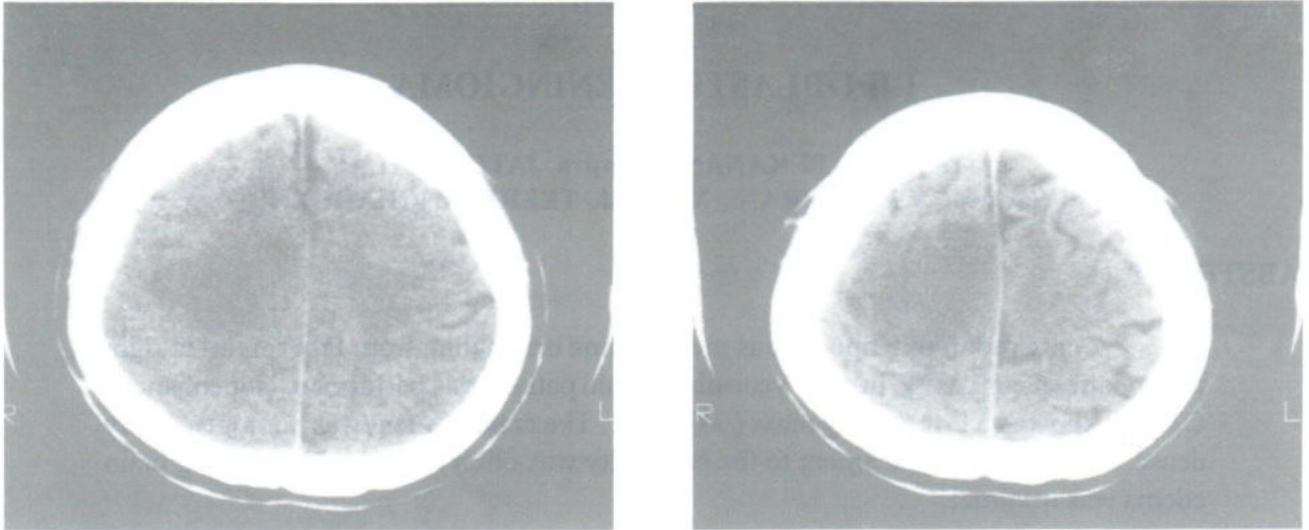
NCE CT scan of the near vertex of the brain showed an indistinct border low density mass at right frontoparietal lobe, mild pressure on the adjacent falx was shown.
